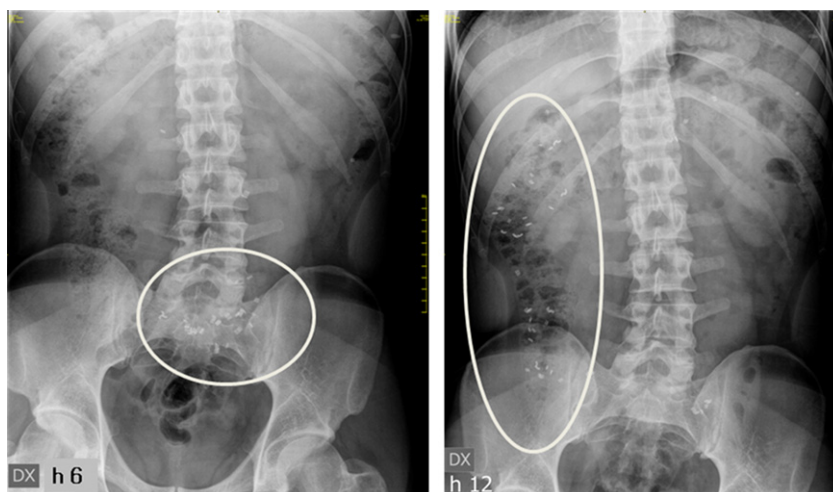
X-Rays image of the intestine of a healthy volunteer 6 h (left) and 12 h (right) after the administration of samples of 3-blade extrudates containing barium sulphate as radio-opaque agent (see Table 1).
